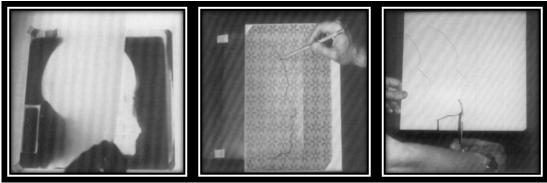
a) Tracing paper is taped to cephalometric radiograph on view box. b) Soft tissue profile is traced onto cardboard. c) Profiles are cut out with scissors.
